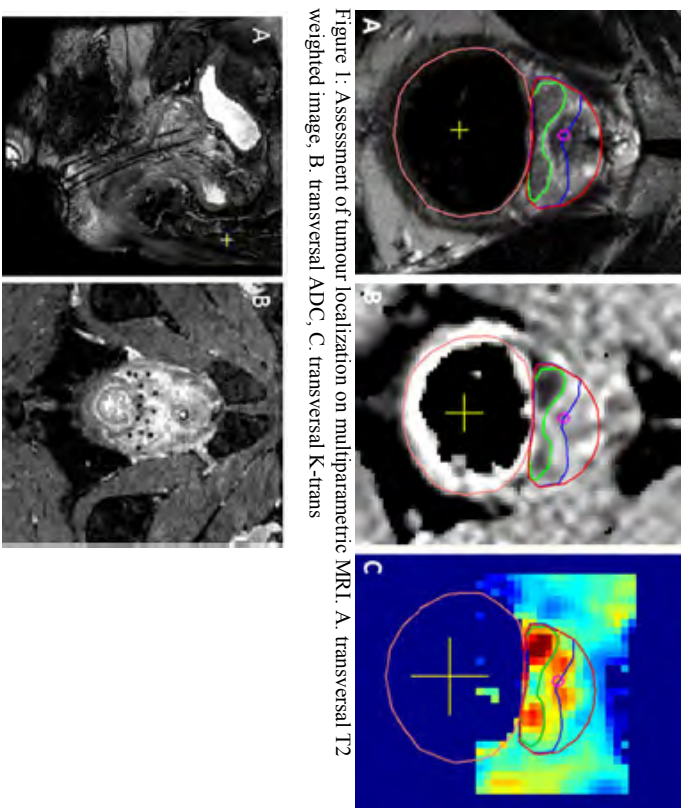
Assessment of tumour localization on multiparametric MRI. A, transverse T2 weighted image, B, transverse ADC, C, transverse K-trans
